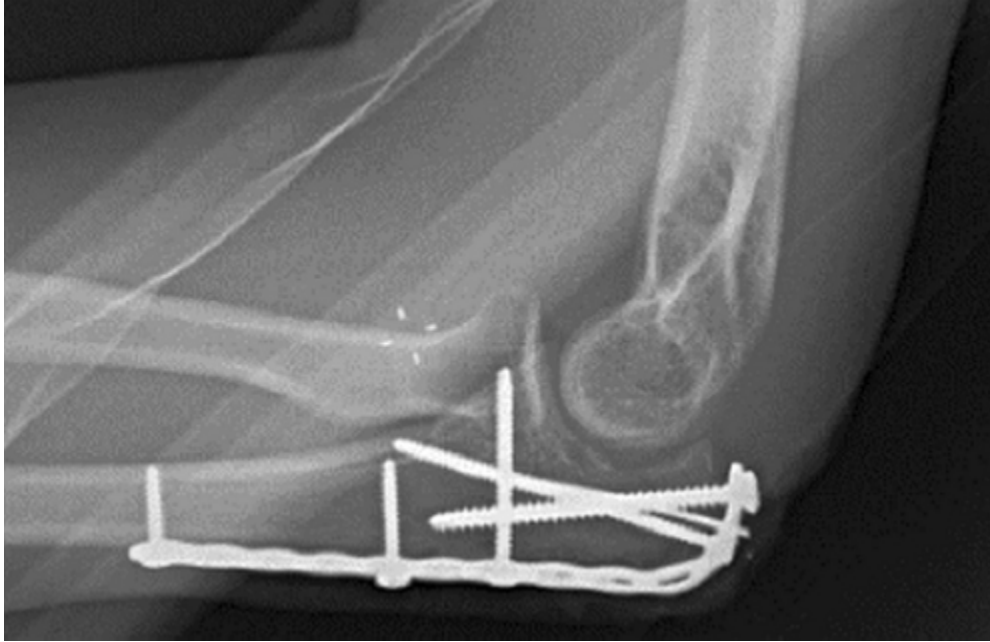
K-wire can be cut flush and retrained. Lateral postoperative radiograph.
